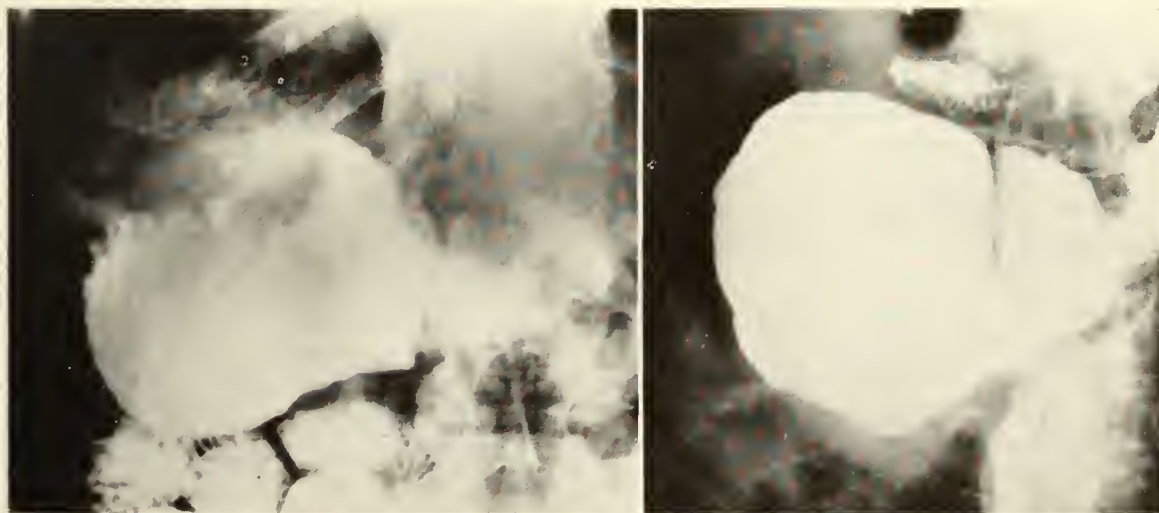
Radiographs of a large tumor of the fundus of the stomach, probably a lymphosarcoma, before and four months after divided dose X-ray therapy. This patient has gained thirty-seven pounds and has remained well for three years.
